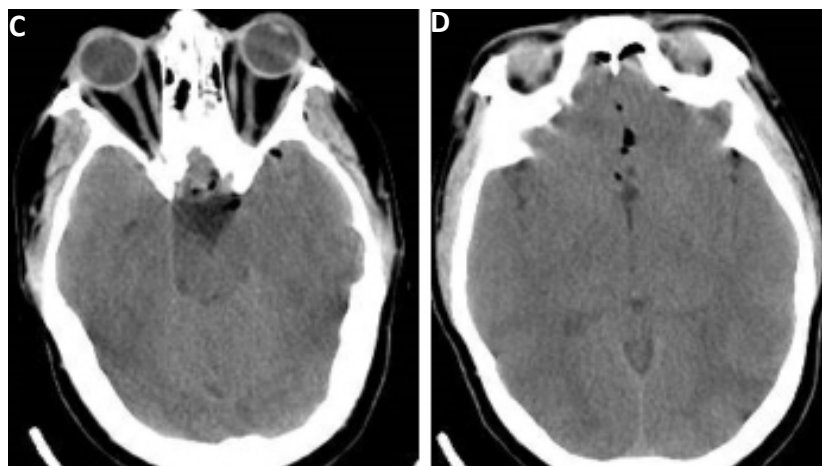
(C&D): Post operative axial non contrast CT showing complete resection of lesion with post operative changes.
